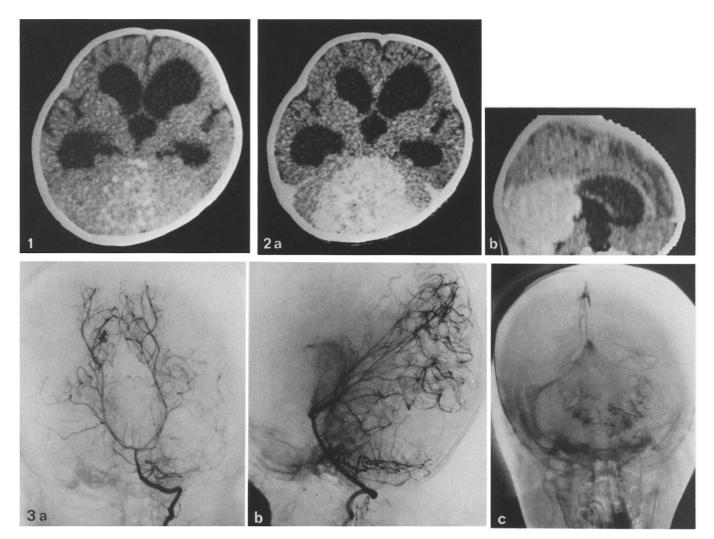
Plain CT shows spotty, high density zone in the median part of the posterior fossa and markedly dilated lateral and third ventricles
